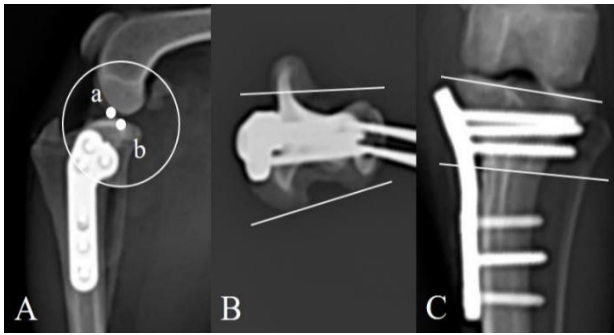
Radiographic measurements of the proximal tibia. Measurement of osteotomy location (A). Point (a) indicates the location of the intercondylar tubercle. After surgery, a circle was drawn along the osteotomy line. The center of the circle is point (b). The distance between point (a) and point (b) was measured. Measurement of craniocaudal and proximodistal orientation line angle (B and C). Two reference lines were measured in the proximal tibia fragments. Reference line 1 (RL1) was the line of the medial and lateral posterior connections of the tibial plateau. Reference line 2 (RL2) was the most distal junction line of the medial and lateral sides of the tibial plateau. The angle between RL1 and the postoperative osteotomy line was termed the craniocaudal orientation line angle (CrCaOLA), whereas the angle between RL2 and the osteotomy line was termed the proximodistal orientation line angle (PrDiOLA).
